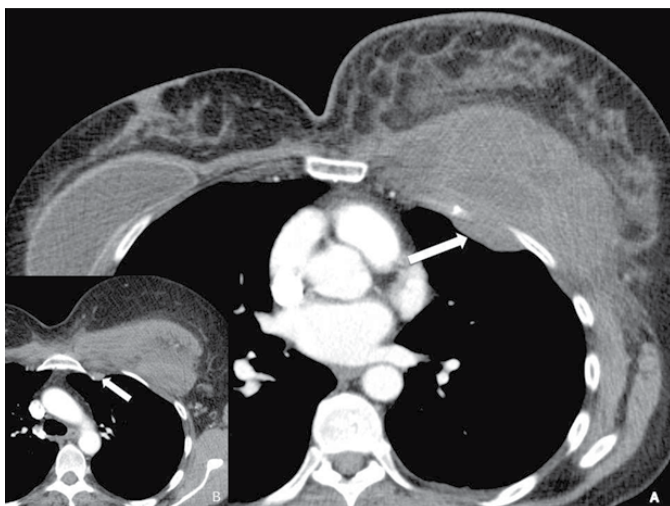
Axial post-contrast computed tomography scan of the chest shows an irregular mass posterosuperior to the left implant (A) invading the chest wall (arrow). A higher cut (B, inset) showing a pathologically enlarged left internal mammary lymph node (arrow).
